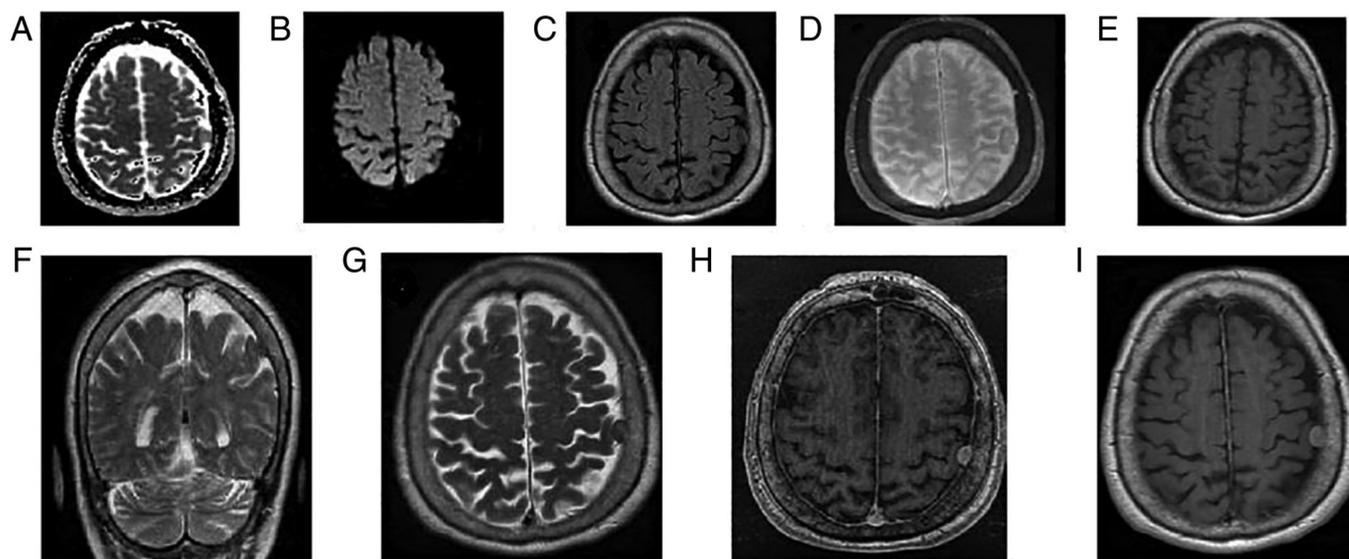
Case 3. (A and B) Axial diffusion-weighted image and the corresponding apparent diffusion coefficient map revealed no diffusion restriction or facilitation on the mass. (C) FSPGR with no contrast. (D) Axial T2 FLAIR-weighted image; and (E) axial T1-weighted image prior to contrast administration. (F) Coronal and (G) axial T2-weighted images revealed an enlargement of the meninges. Following intravenous contrast administration, an (I) axial T1-weighted image post-contrast and (H) FSPGR post-contrast image revealed a small well-circumscribed, extra-axial mass on the left cerebral convexity. The mass exhibited homogeneous hyperintensity compared with the gray matter.
